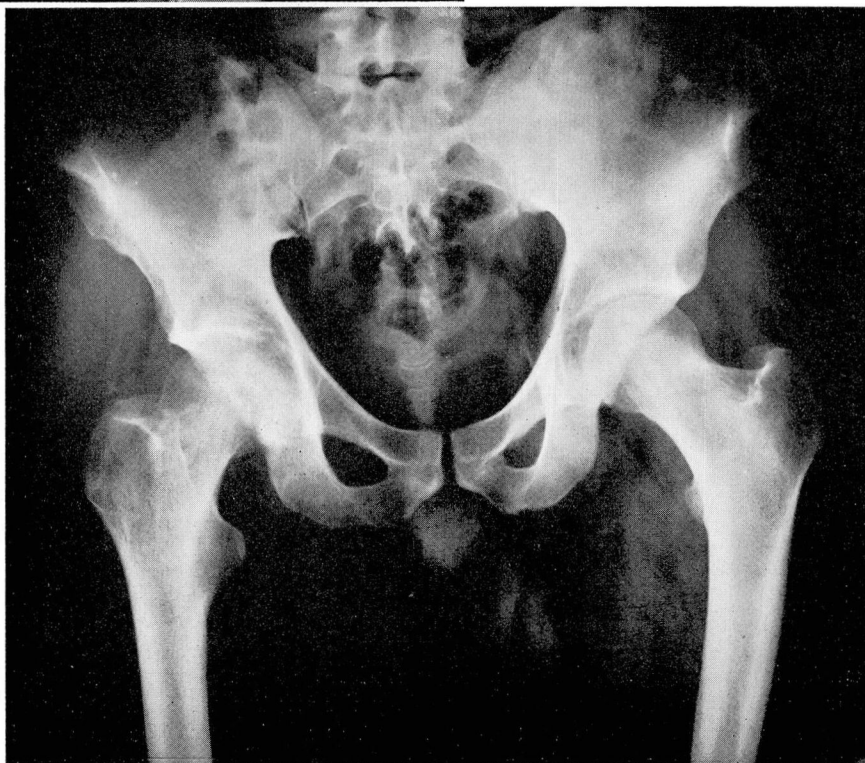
Two reproductions of one roentgenogram of a pelvis. The conventional print shows extreme range of contrast densities that are softened in the masked print.
